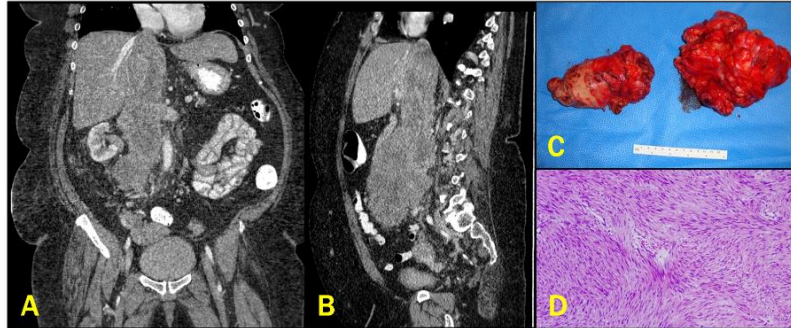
(A) Coronal contrast-enhanced CT scan showing a large intraluminal mass within the inferior vena cava, extending to the right atrium. (B) Sagittal reconstruction confirming the cranial trajectory of the mass along the IVC.
